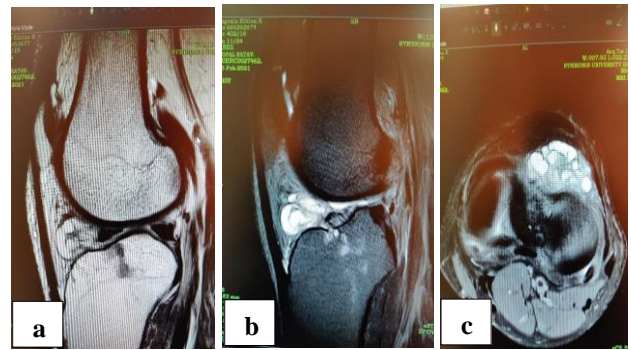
MRI images T1 and T2 images of left knee (a) T1 image and (b and c) T2 image of MRI suggesting hyperintense lesion.
